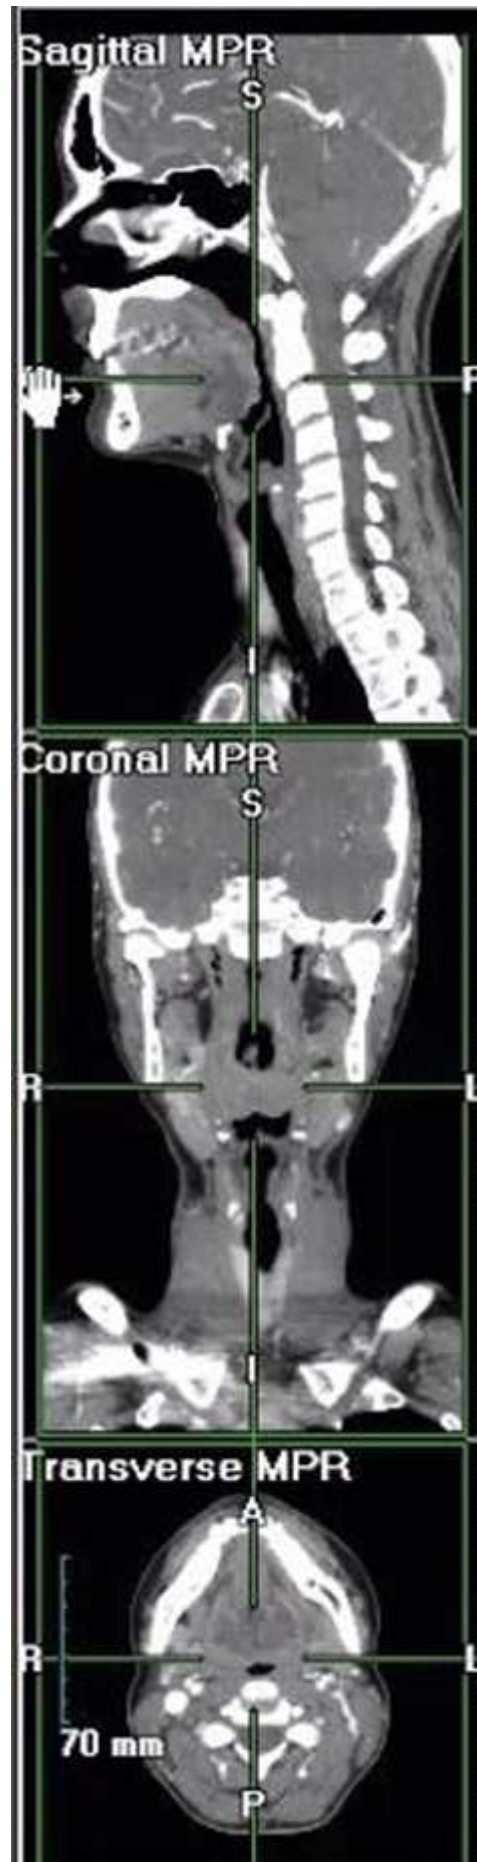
CT multiplanar reformat (MPR) of the head and neck. From Weber State University, School of Radiologic Sciences.
